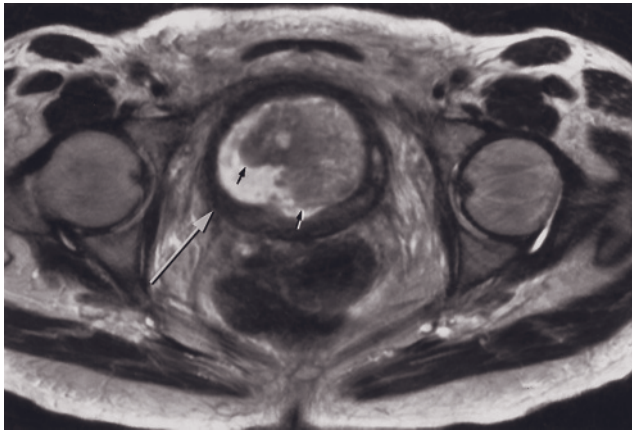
(Continued) T1-weighted gadolinium-enhanced fat-suppressed SGE (*b*) images in a third patient demonstrate a mildly enhancing soft-tissue mass that arises from the left posterolateral bladder and extends into the paravesical fat (arrows, *f-b*). Sagittal T2-weighted high-resolution fast spin-echo (*i*), single-shot echo-train spin-echo (*j*), and T1-weighted 90-s postgadolinium fat-suppressed 3D-GE (*k*) images in another patient with squamous cell cancer images show diffuse thickening of the bladder wall. The bladder wall demonstrates irregular thickening and heterogeneous signal on high-resolution T2-weighted image (*i*) but enhances homogeneously on postgadolinium image (*k*). In the bladder lumen, there is hematoma showing low signal on T2-weighted images (*j*) and intermediate signal and no enhancement on postgadolinium image (*k*).
